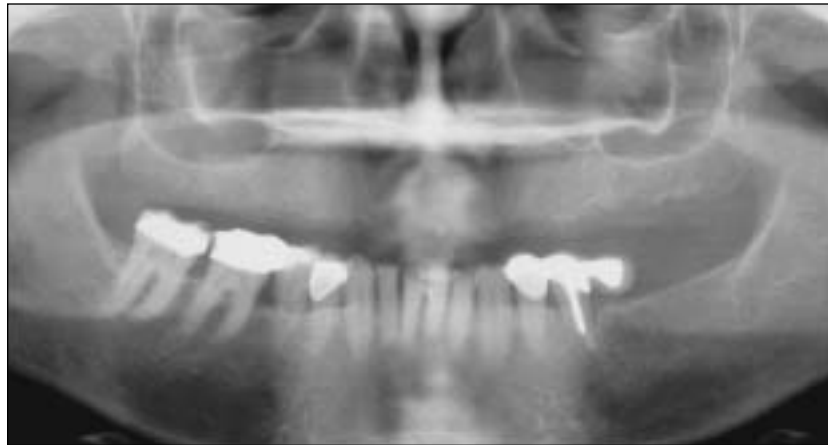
The panoramic radiograph showed adequate bone height mesial to the second premolar positions bilaterally. The inferior border of both antra precluded placement of implants in the molar regions without sinus augmentation.
